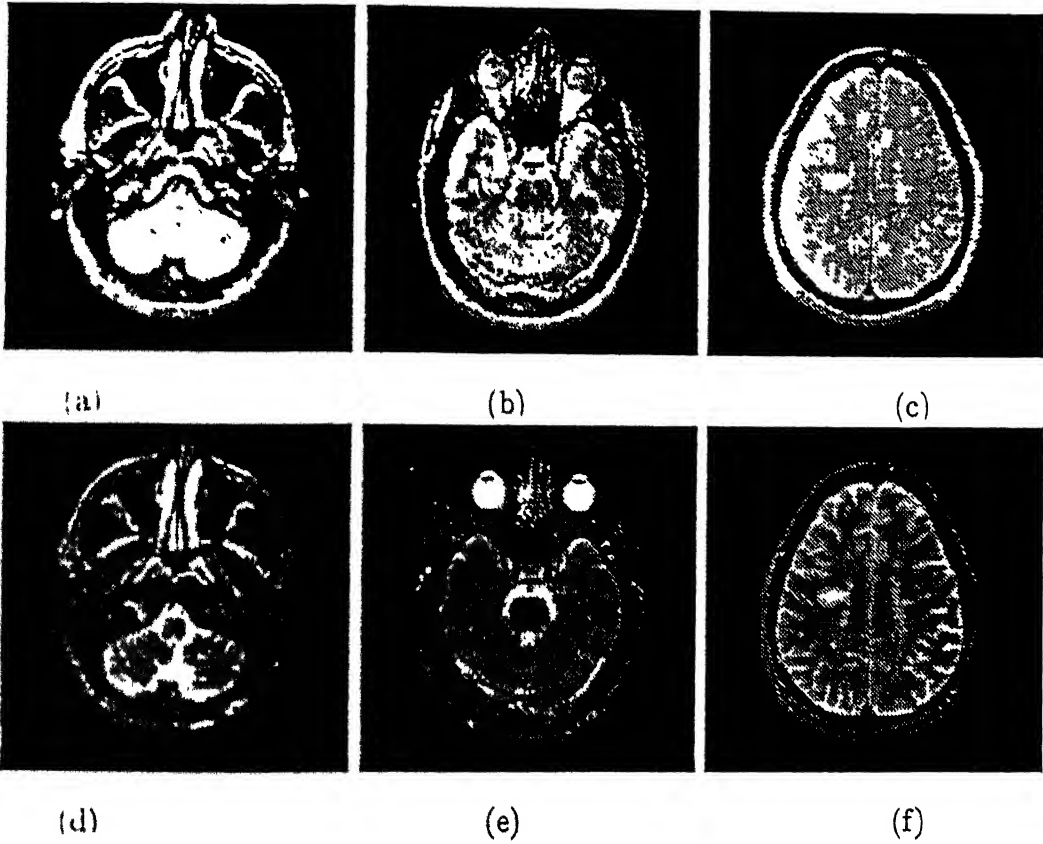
Selected Slices from MRI Data Set 3. (Top) PD-weighted. (Bottom) T2-weighted. (a),(d) Slice 4. (b),(e) Slice 9. (c),(f) Slice 19.
